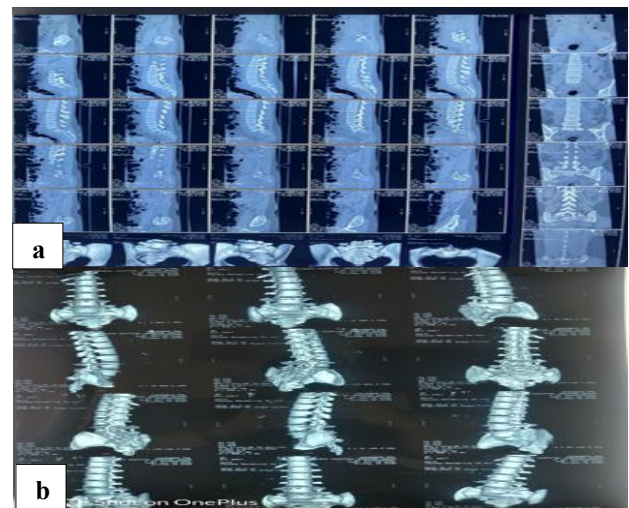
(a and b): Three-dimensional CT reconstruction of the pelvis showing fracture configuration and sacral instability.
